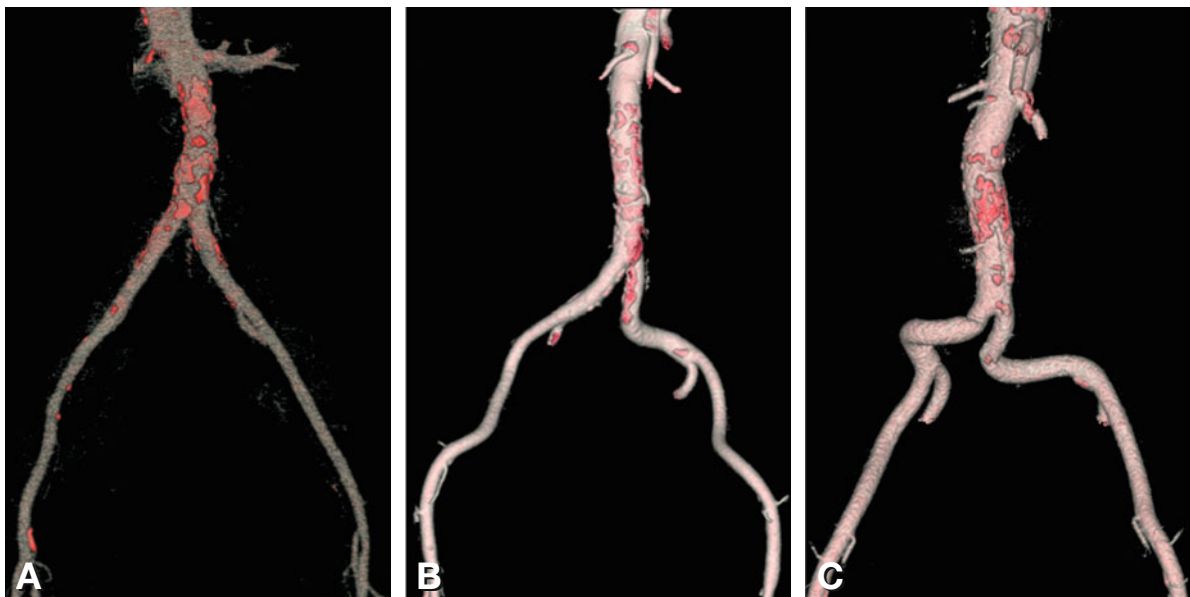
Importance of obtaining pre-TAVI angiography images with CT (shown here are three-dimensional reconstructions of the abdominal aorta and the iliofemoral arteries in three patients). In Panel A, vessels are moderately calcified and completely straight. In Panel B, tortuosity is moderate. The femoral approach was used in both patients Panel C shows iliac artery sections with severe bilateral tortuosity, contraindicating a femoral retrograde approach. A transapical route was therefore chosen
